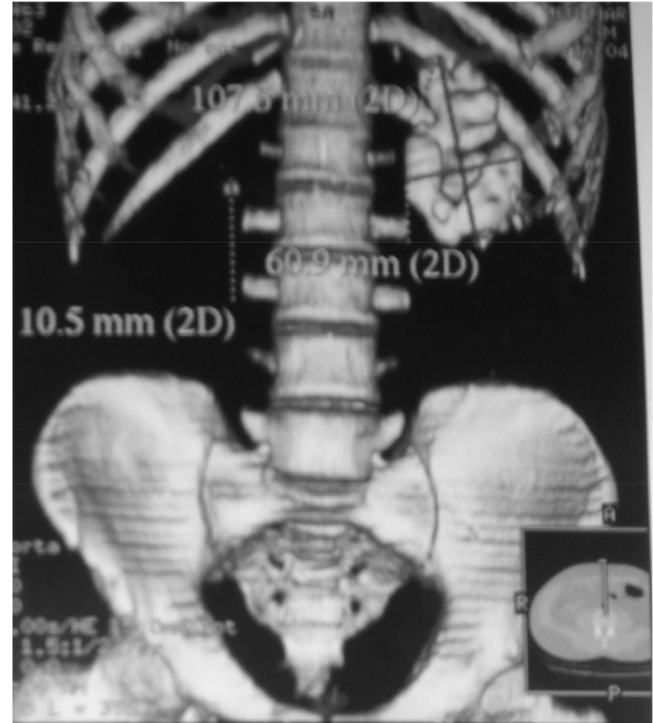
CT with reconstruction shows hydronephrotic kidney with multiple stones.
